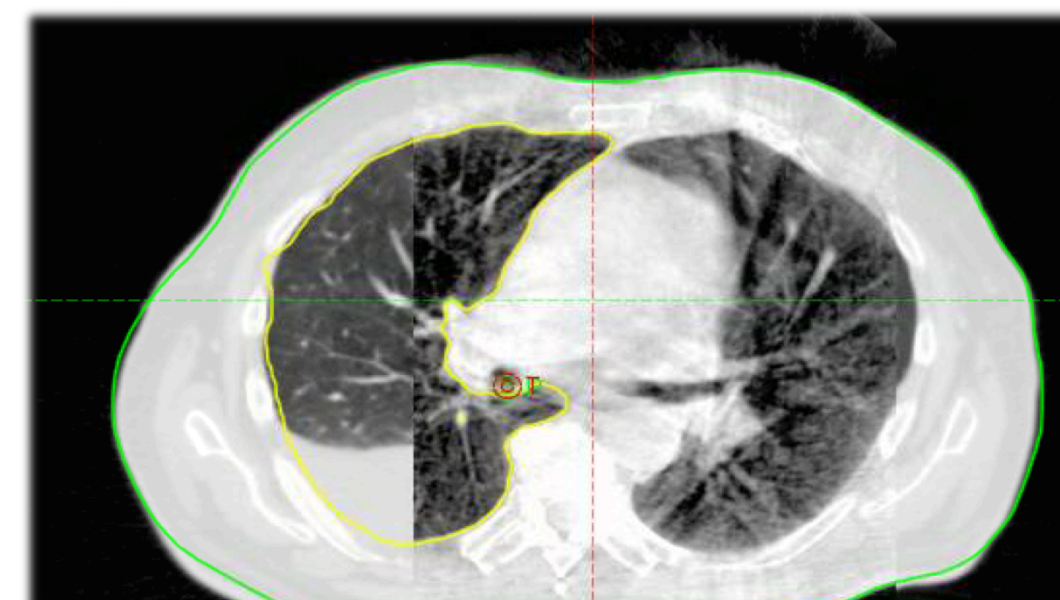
CBCT showing re-inflation of the lung, referred to the treatment planning IGRT lead to assess
